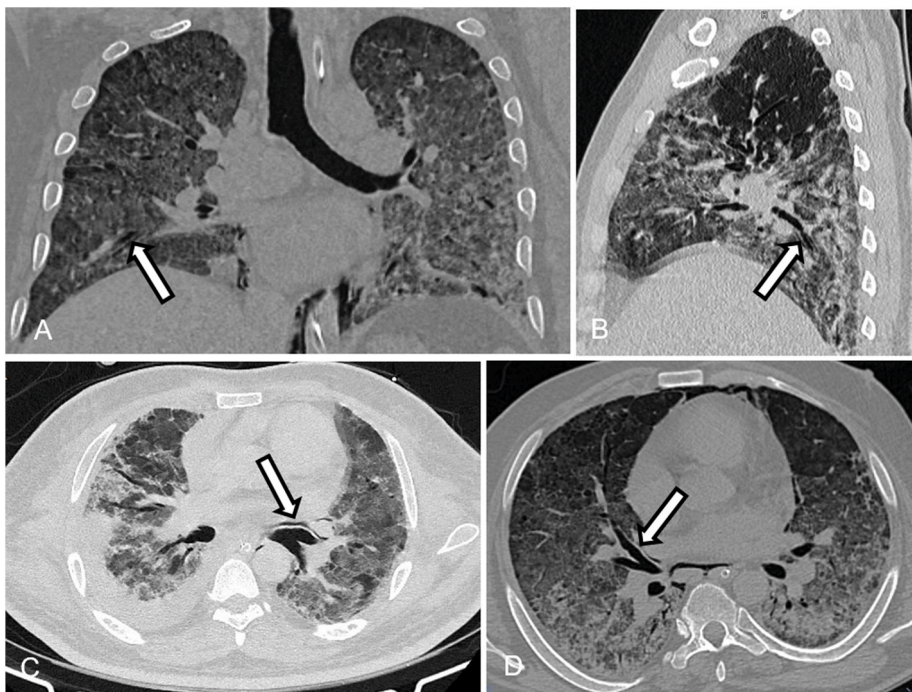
Coronal reformatted (A), Sagittal reformatted (B) and axial (C and D) CT images in lung window showing the presence of Macklin effect i. e air dissection along the peribronchovascular sheaths (marked by white arrow).
